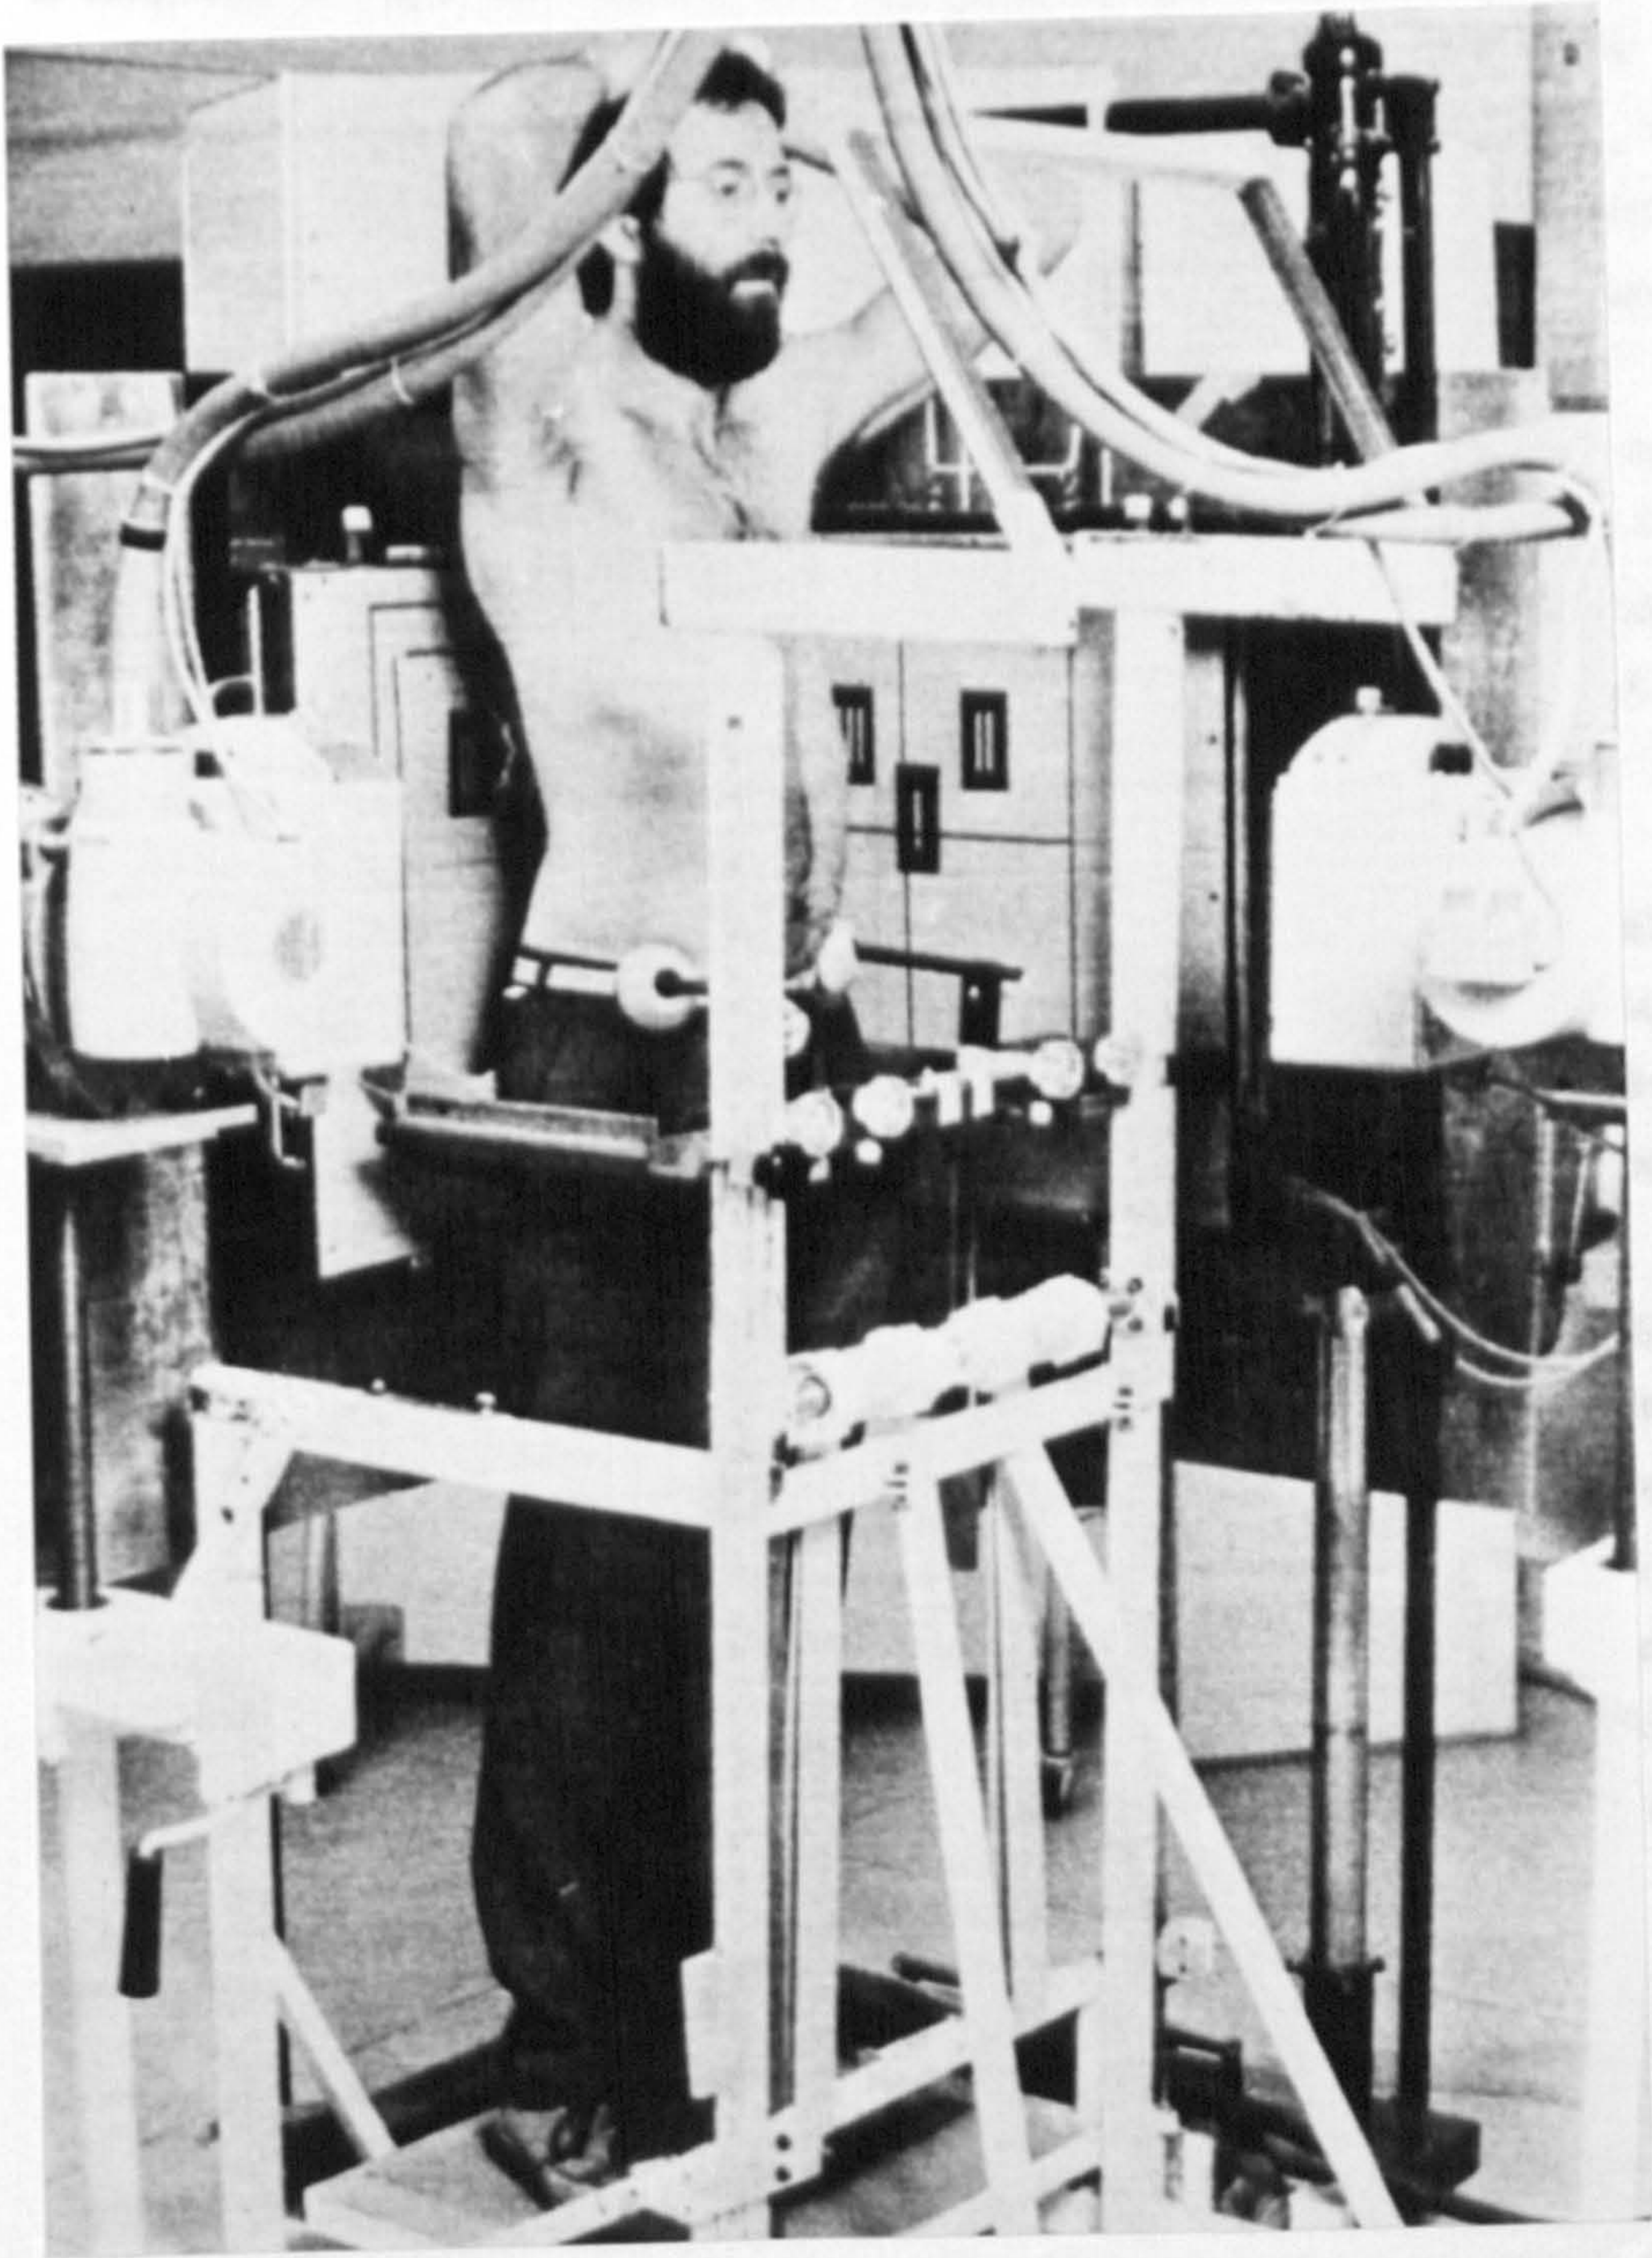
Stereo-radiography - Lumbar Spine
